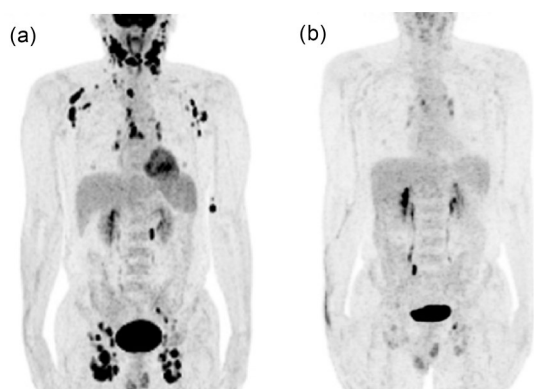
PET/CT scan of Case 3. (a) PET/CT before treatment in February 2021 showed the involvement of multiple lymph nodes (left parapharyngeal, left preauricular, bilateral neck, bilateral clavicle region, bilateral armpit, mediastinum, bilateral hilum, para-aortic, bilateral internal iliac, bilateral groin, and subcutaneous soft tissue of left lower humerus) along with increased FDG uptake; (b) PET/CT after treatment in July 2021 showed that primary lesions had significantly shrunk or reduced in size, and there was no increase in FDG uptake. PET: positron-emission tomography; CT: computed tomography; FDG: fluorodeoxyglucose.
